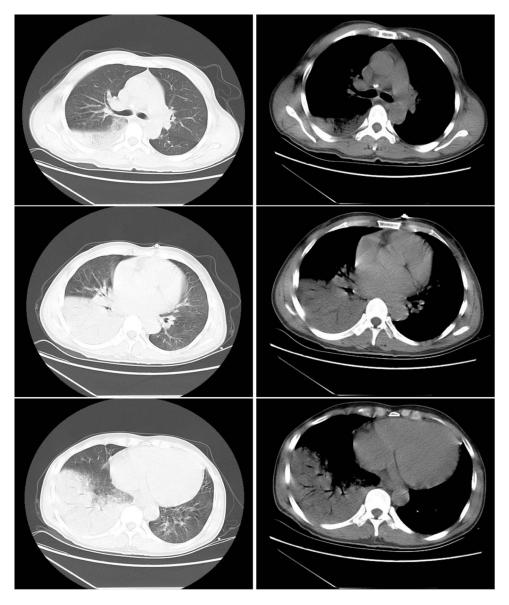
Figure I CT image of the chest before the treatment of pneumonia caused by Chlamydia abortus.
